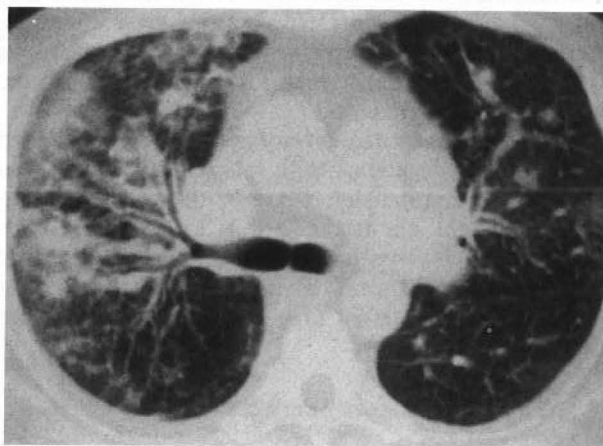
CT scan at the level of right upper lobe: interstitial and peribronchial infiltration.
